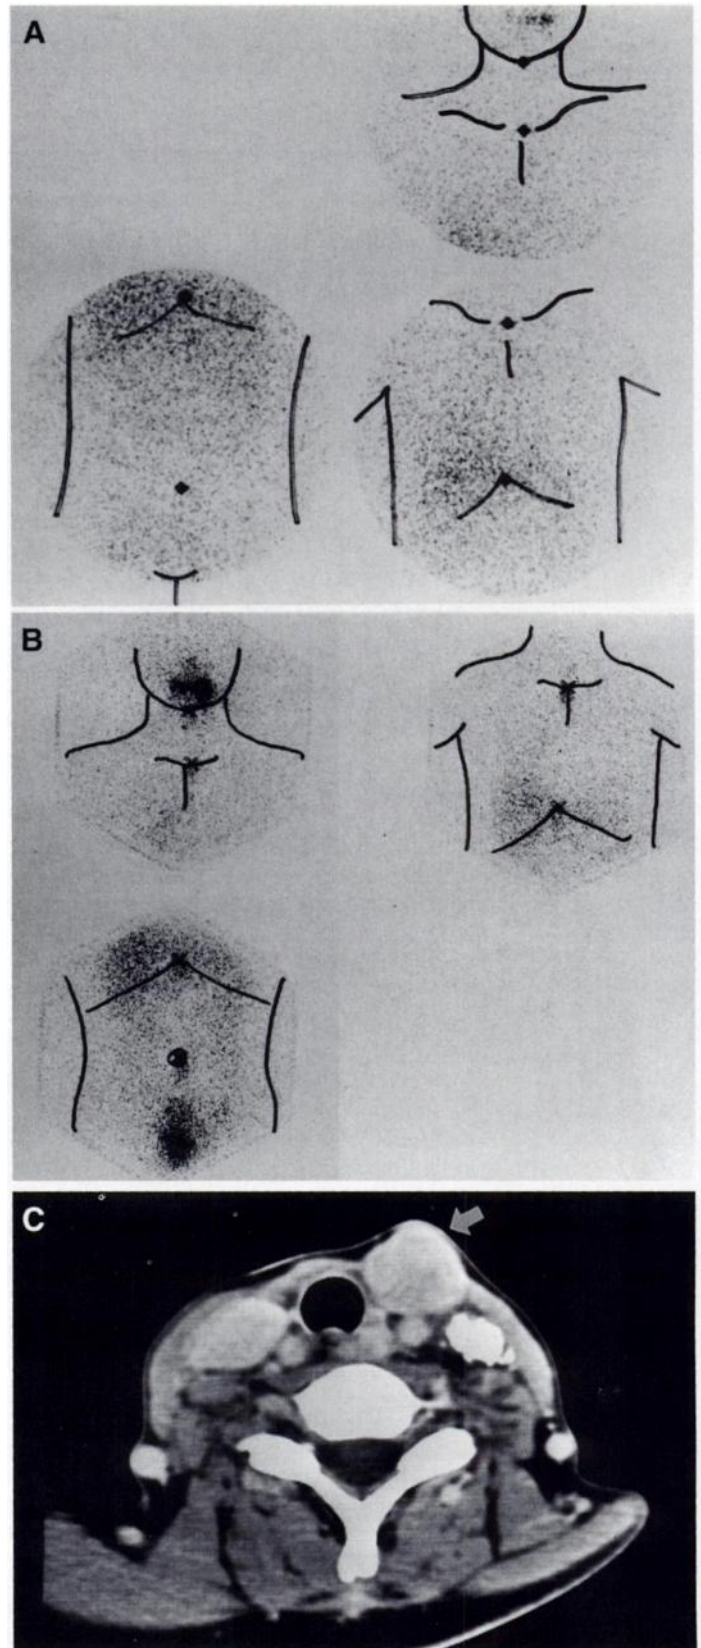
Anterior images of ^{131}I whole-body scan in Patient 5. (A) Whole-body scan showed Grade 2 liver uptake and no metastatic lesion. (B) Thirty-one months later the whole-body scan still showed liver uptake only. Serum level of Tg was very high, 152.3 ng/ml. (C) CT of the neck revealed enlargement of left cervical lymph nodes (arrow), which during reoperation was confirmed as metastases.
